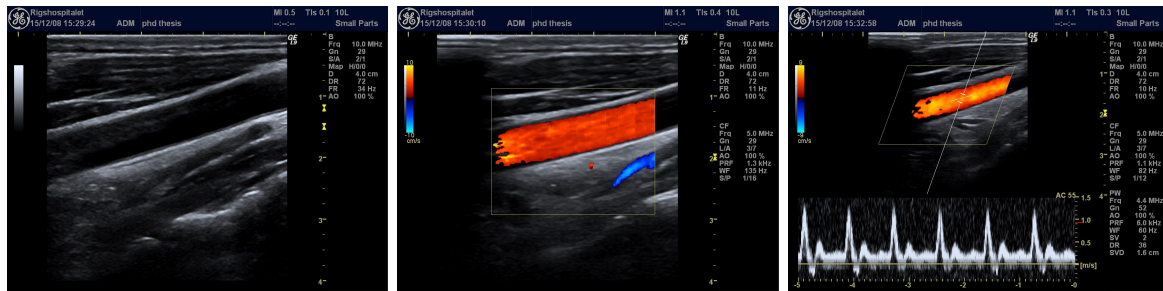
Frame rate decreases from 34 Hz to 10 Hz when adding color flow mapping and spectral Doppler to B-mode imaging. Frame rate is on the screen denoted FR.
